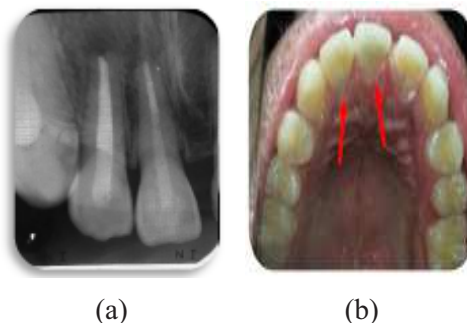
(a) Post operative periapical radiograph showed good adaptation between fiber post and root canal dentin on tooth 11 and good coronal sealing on tooth 12 (b) Post operative clinical photograph of tooth 12 11 from palatal aspect (red arrow).
